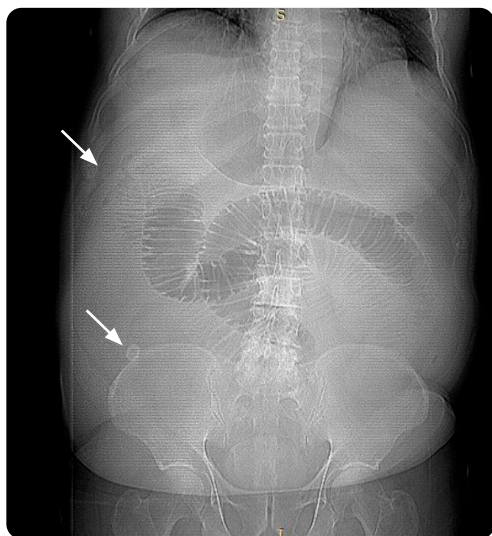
Standing abdominal X-ray: Significant distension of the small intestinal loops, as well as the gastric chamber, portal gas and intrahepatic portal branches (blue arrow). In the lower right quadrant there is rounded calcification corresponding to calculus at the level of the ileocecal valve (arrowhead).
